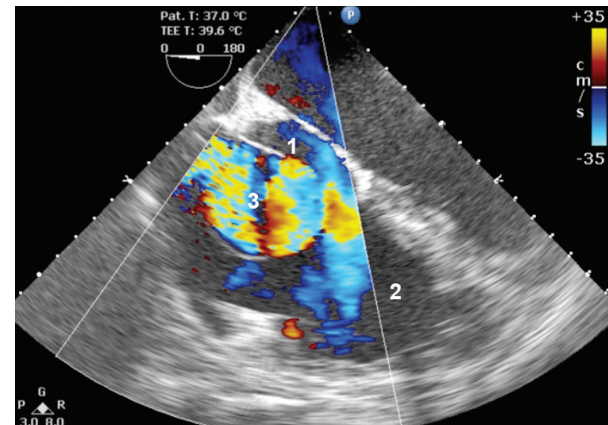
Two-dimensional transoesophageal echocardiogram with Doppler in short-axis view. 1, right atrium; 2, right ventricle; 3, aneurysmal sac. Turbulent flow is demonstrated within the aneurysmal sac, which empties into the right atrium through a defect in the wall of the sac, thus creating the left-to-right shunt.
